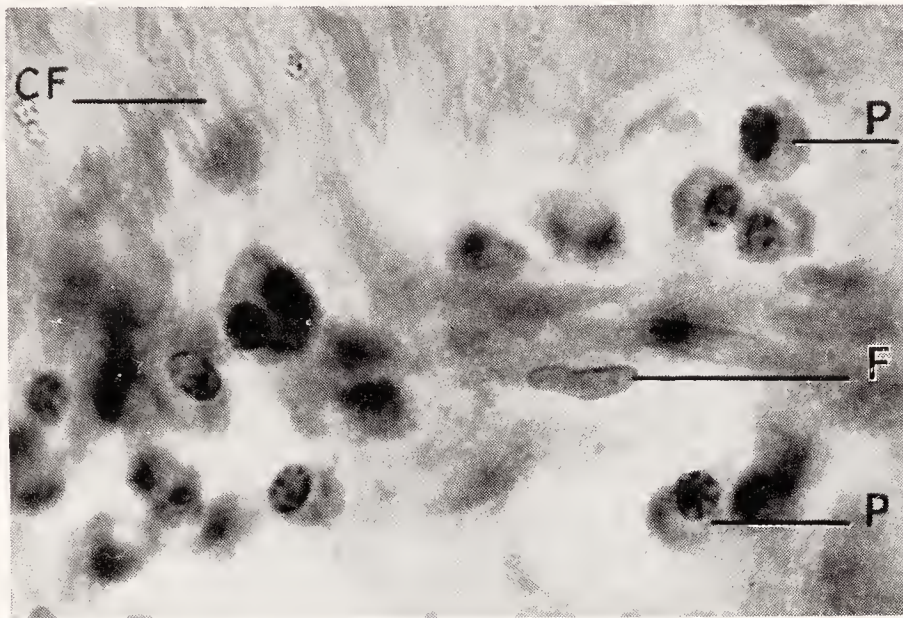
Typical cell forms in chronic inflammation of the periapical tissue. *P*, plasma cells (polyblasts) with “cartwheel” nuclei; *F*, fibroblast; *CF*, connective tissue fibrillæ.
